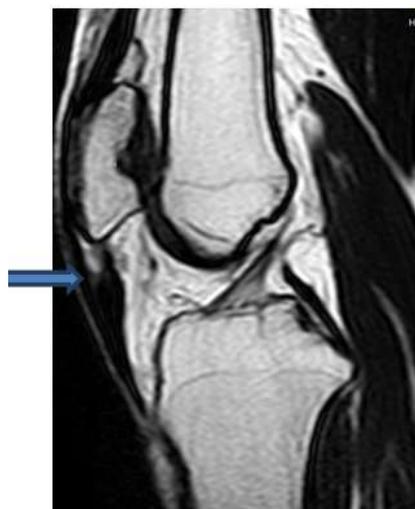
T1-weighted sagittal image reveals marked thickening and hyperintensity within the patellar tendon (arrow) with subtle interstitial splits.
